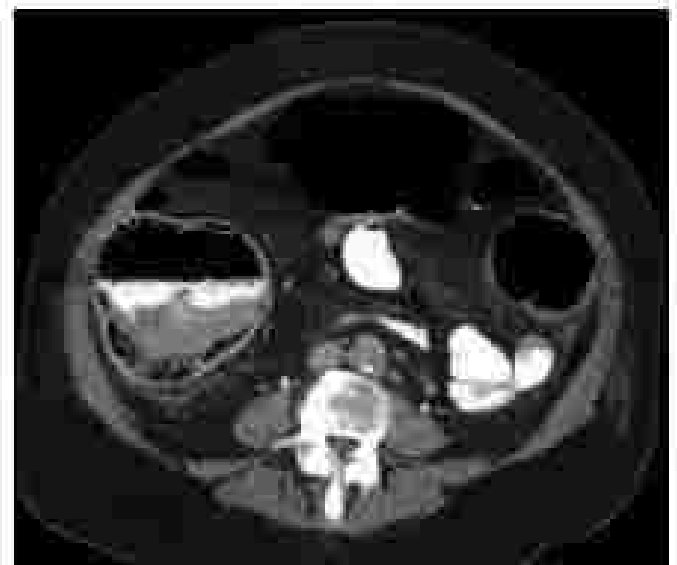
Computed tomography scan demonstrating axial view of colonic dilation, diffuse colitis with thickening, mucosal edema, and pericolic fat stranding characteristic of toxic megacolon.
